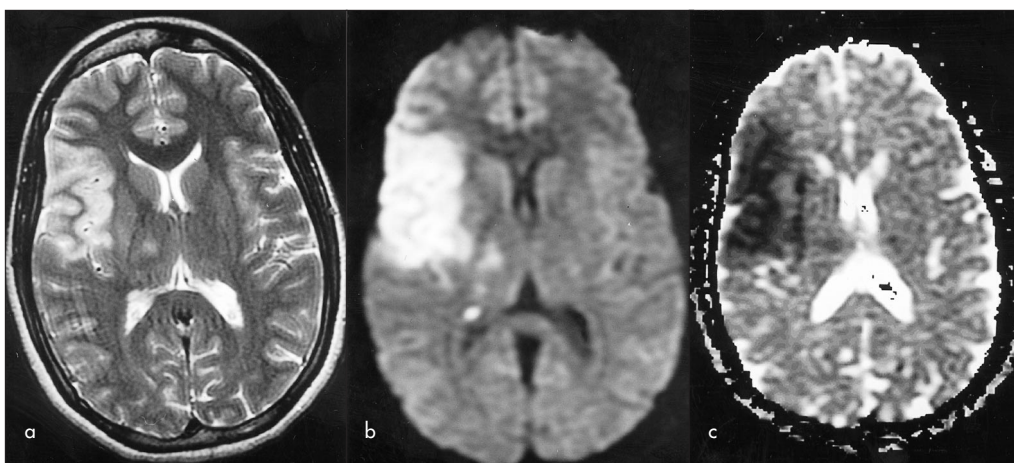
a. T2-weighted magnetic resonance image (MRI), (b) diffusion-weighted MRI and (c) apparent diffusion coefficient (ADC) map of a 30-year-old patient with an acute right hemisphere stroke. a. The T2-weighted image shows some high signal in the right insular cortex and internal capsule. There is a more extensive area of restricted diffusion which appears bright on (b) the diffusion-weighted image and dark on the ADC map (c). Note that the lesion is most obvious on the diffusion-weighted image but the ADC map is a more accurate reflection of the diffusion abnormalities, independent of any T2 effects.
